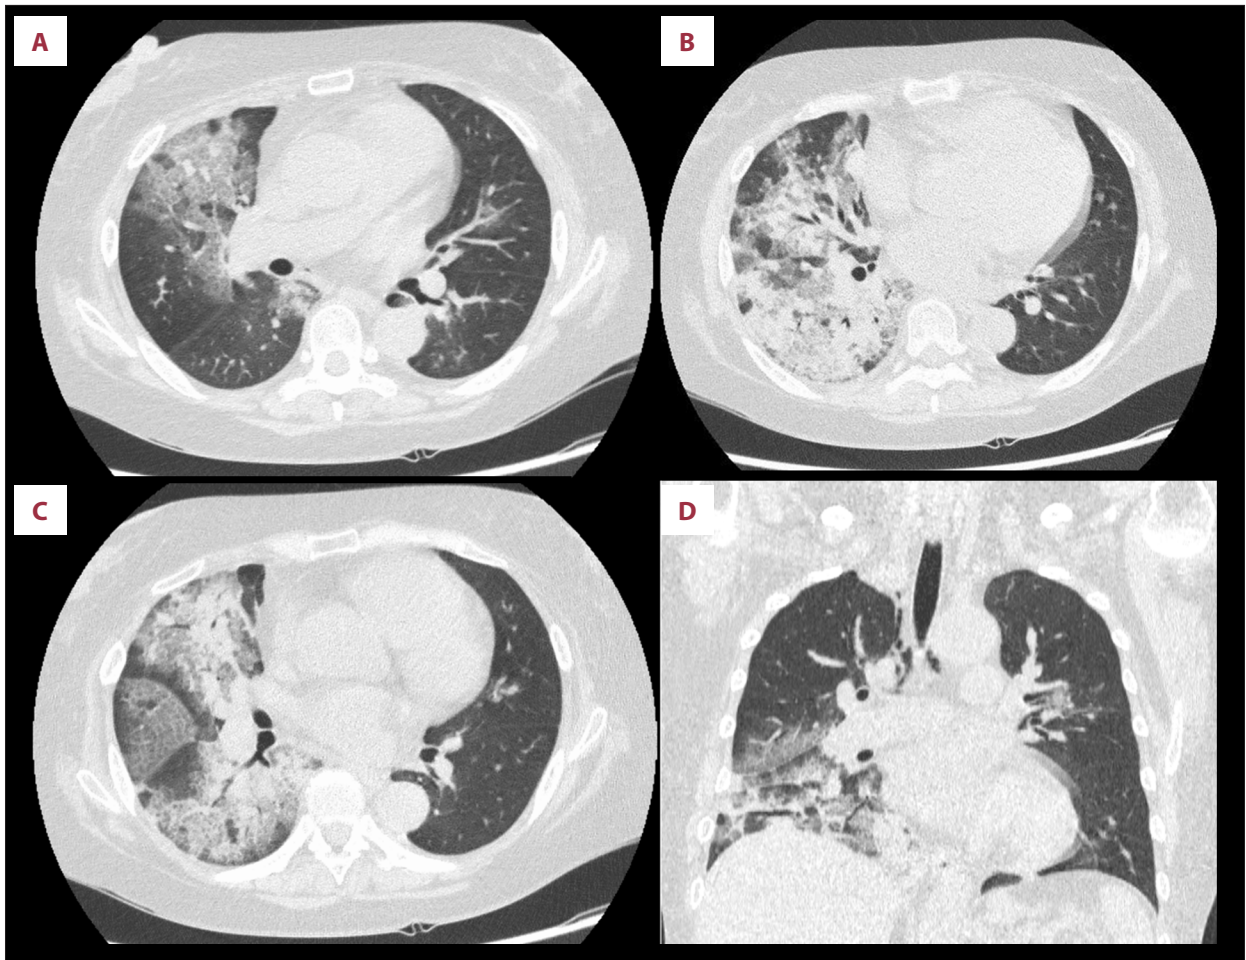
CT on admission. The axial plane of chest CT showed pulmonary consolidations with a confluent appearance and signs of air-bronchogram in the right middle (B) and inferior lobes (C). Consolidations associate with interspersed areas of ground-glass opacities with superimposed intralobular septal thickening, defining a “crazy-paving” pattern in the right upper (A) and middle lobe (B) and sparing some secondary lobules. The coronal plane on chest CT showed the distribution of parenchymal findings (mostly right lung area in D) and pneumomediastinum (arrow, D).
